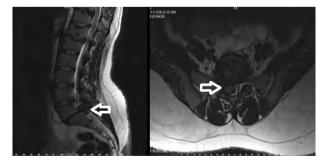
Sagittal and transvers T2-weighted MRI of the lumbar spine shows giant mass of extruded disc herniation that was at the L5-S1 intervertebral disc level and compressed right S1 nerve root or pathological mass
